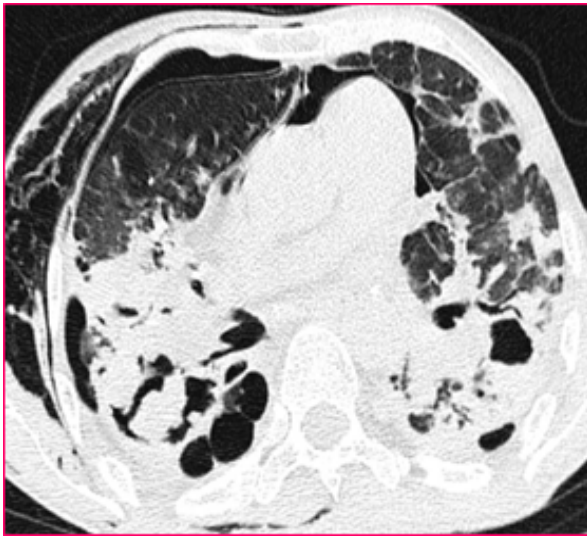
CT thorax lung window in axial view demonstrating fungal ball/Aspergilloma (3 %) seen in the cavity in the right lower lobe. Subcutaneous emphysema is also seen on the right side.
